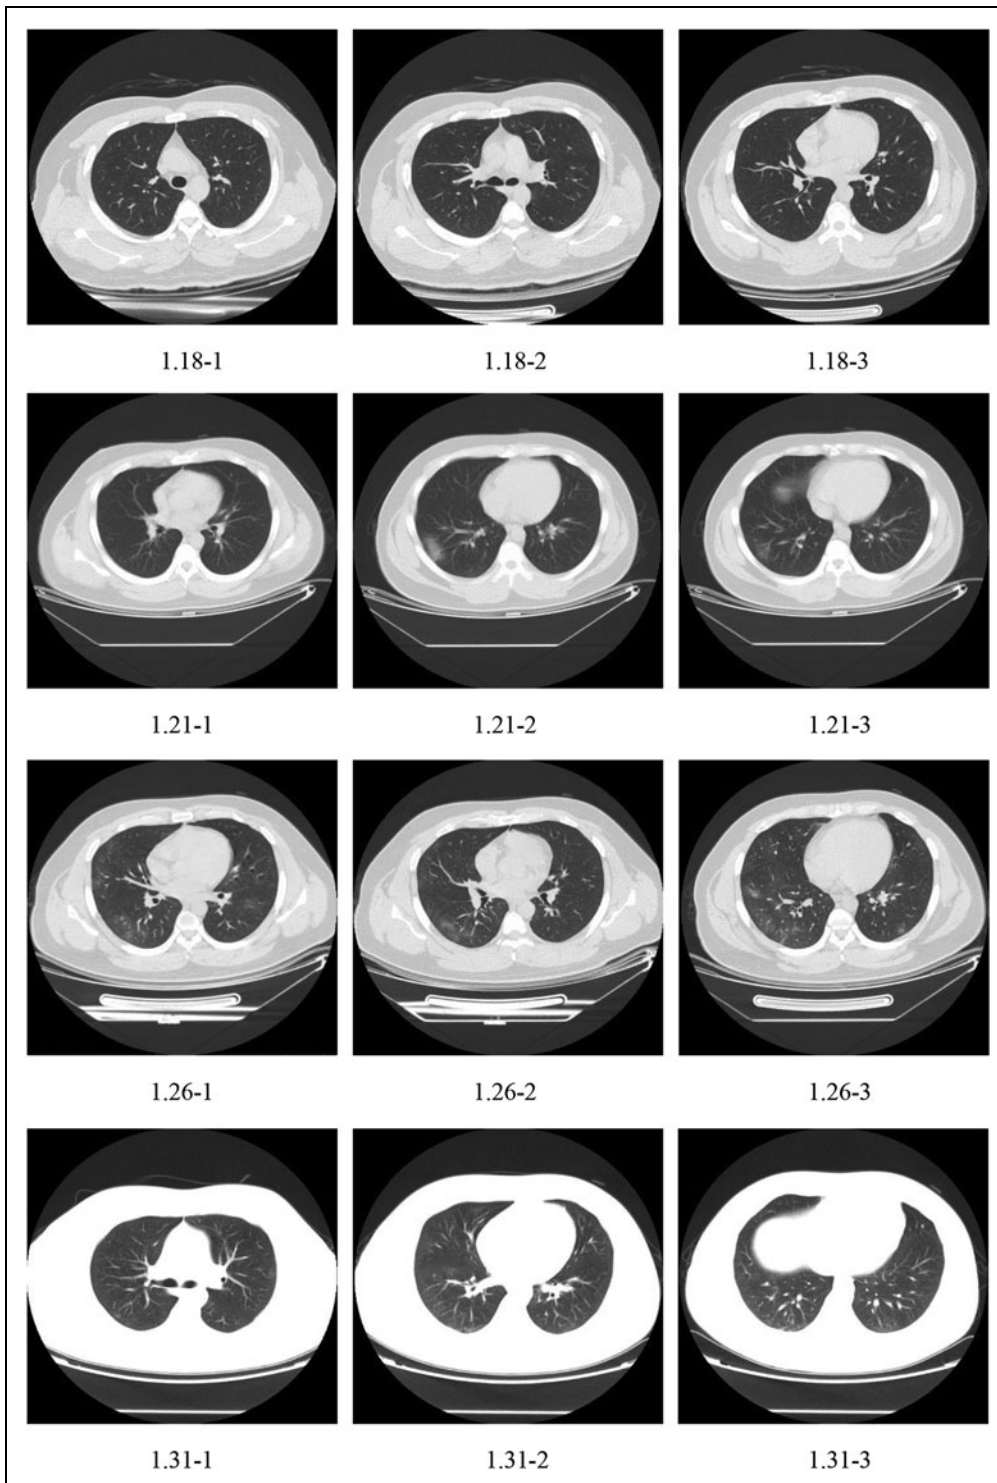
Changes in CT results of case 1. CT, computed tomography.
